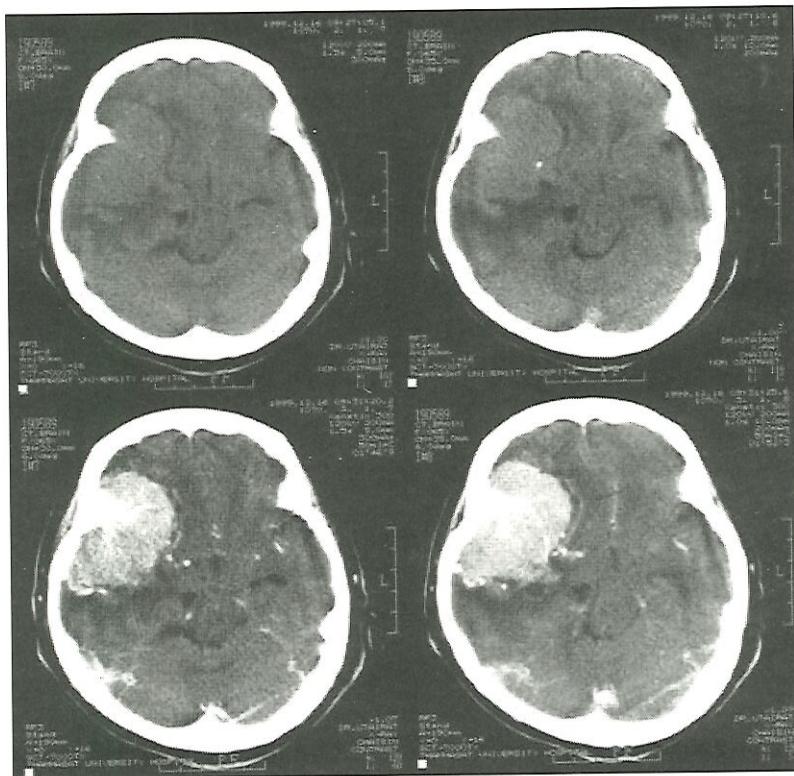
Pre- and post-contrast enhanced CT showed a large hyperdense mass with few small calcifications and intense homogenous contrast enhancement at right frontoparietal (sphenoid wing) region. Compression of right lateral ventricle was noted with subfalcine herniation.
